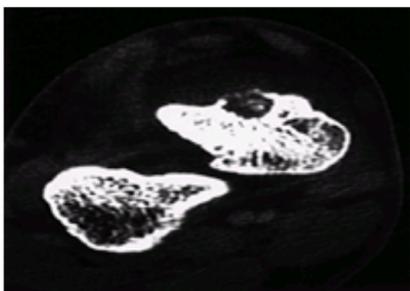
The density of a lesion can be measured on a computed tomography scan. This cortical bone lesion is an osteoid osteoma. The radiologist can measure the actual density of the lesion and provide information regarding the type of tissue. The measurements are made in Hounsfield units, after a developer of computed tomography. Zero Hounsfield units is the density of water. Negative units are less dense than water (fat measures approximately -70 Hounsfield units), and positive units are more dense than water (cortical bone measures greater than 1,000 Hounsfield units).
